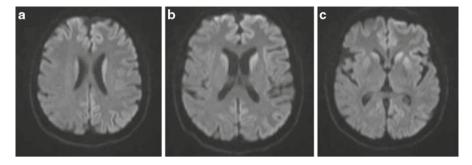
DWI from patient with CJD representing. (a) hyperintensities cortical, (b) symmetric both caudate nucleus plus cortical, and (c) striatum right>left plus cortical
